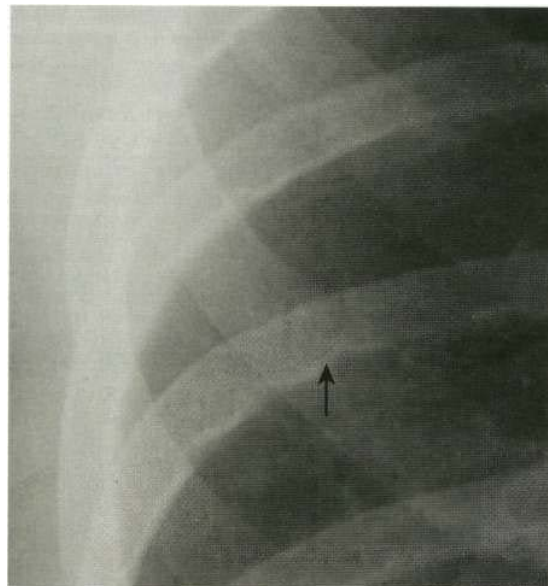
Chest X-ray close-up of right posterior ribs showing rib-notching (arrow).
